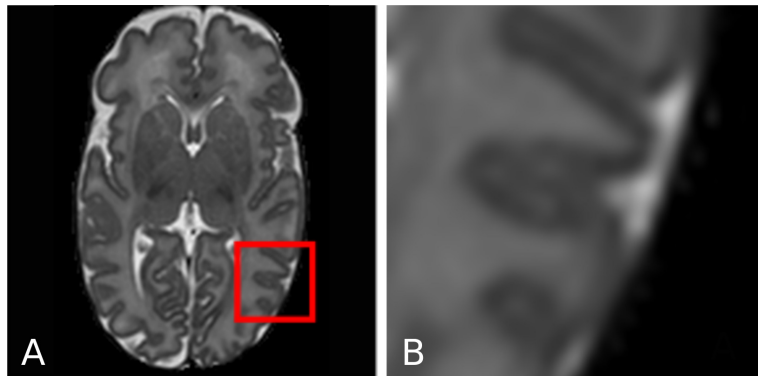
Axial slice of a T2-weighted MRI (A) and magnified region of the cortex (B). Due to PV effects, the CSF inside the cortical sulci is often hard to discriminate, and consequently delineate with intensity-based segmentation techniques.
